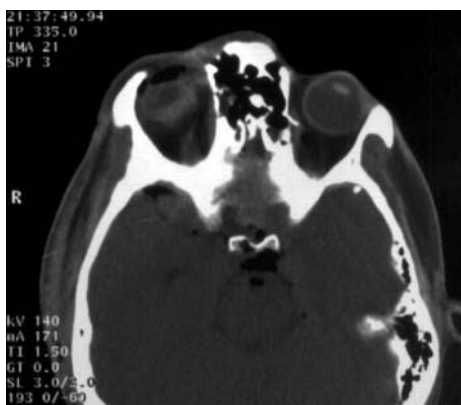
Computed tomogram of the head showing fracture line through ethmoidal labyrinth extending to medial wall of left orbit with fragment of bone abutting left medial rectus. The right penetrating eye injury can also be seen.
